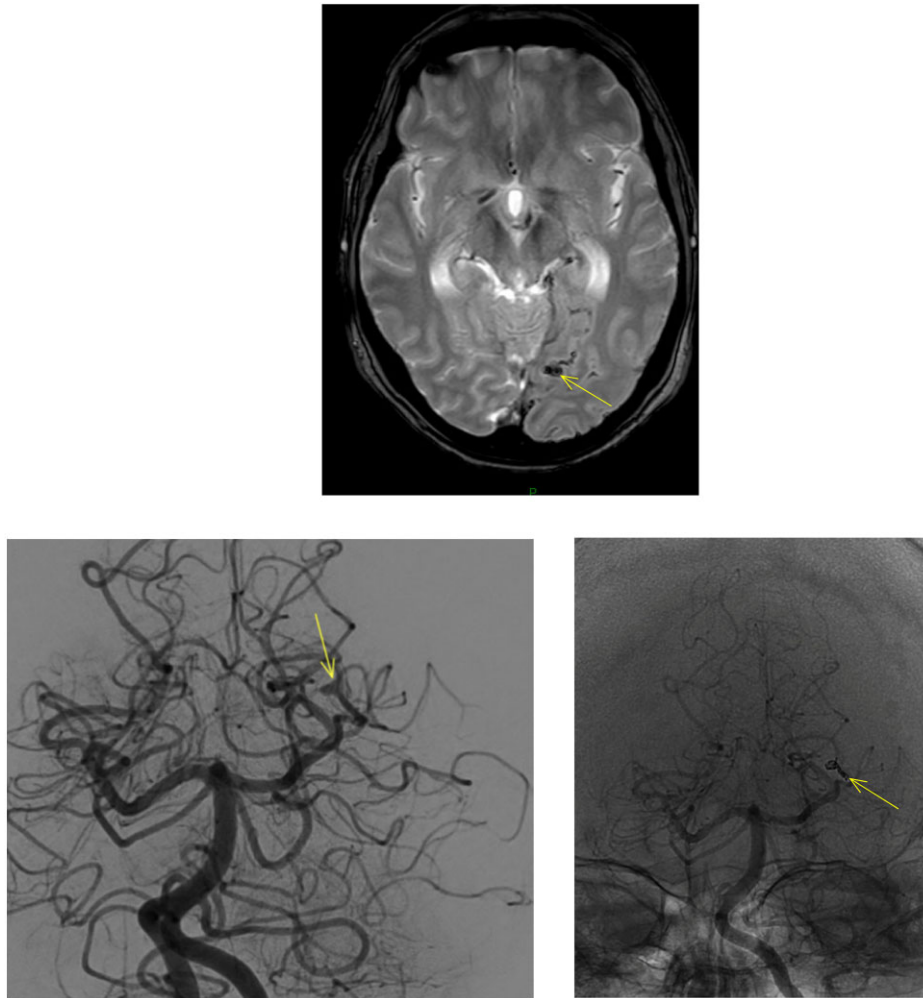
Brain magnetic resonance imaging showed in a T2-enhanced steady-state gradient echo sequences a left internal occipital sub-arachnoid haemorrhage (upper panel, indicated by the arrow) and cerebral angiography demonstrated a mycotic aneurysm of the left cerebral posterior artery before (lower left panel, aneurysm indicated by the arrow) and after endovascular coiling (lower right panel, coil indicated by the arrow).
